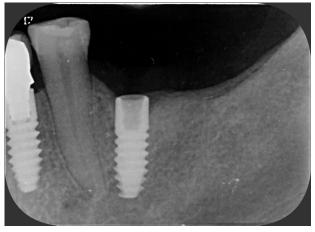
Radiograph showing implant #19 with a fractured abutment screw at the thread level (ASF-3)
